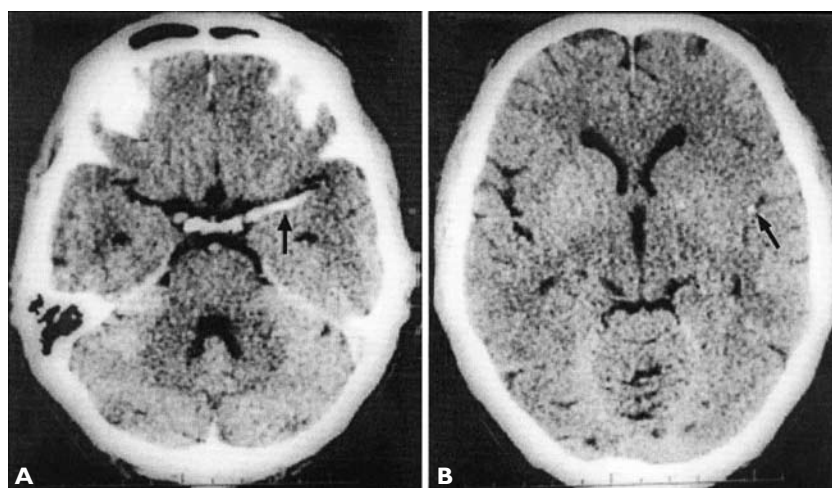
Noncontrast computed tomography scan demonstrating intraluminal thrombus with (A) hyperdense middle cerebral artery (MCA) sign (arrow) and (B) sylvian fissure MCA “dot” sign (arrow).
